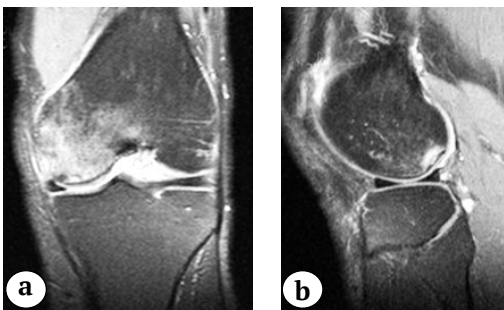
MRI picture of the aseptic necrosis zone of the femoral condyle intero-posterior compartment in T1 mode: a — coronary section; b — sagittal section
